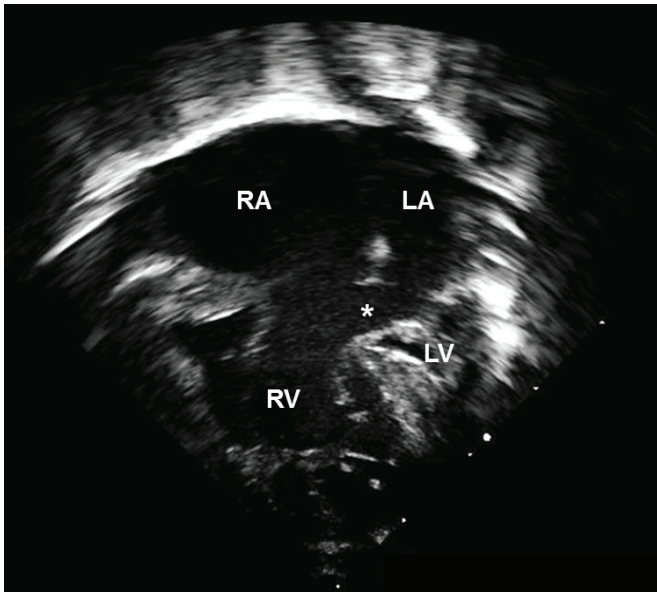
Echocardiogram, 4-chamber view demonstrating a large septum primum atrial septal defect.
